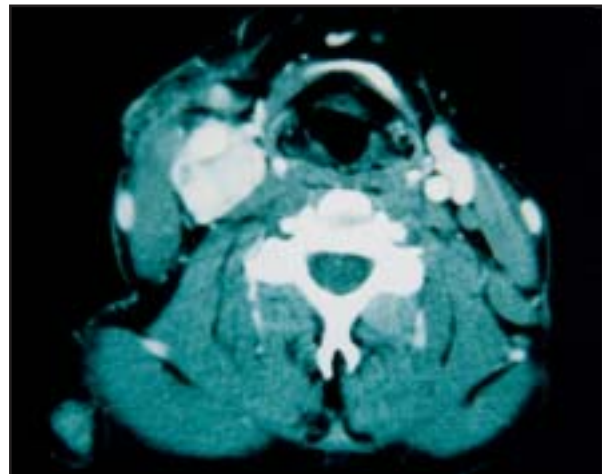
CT scan of the neck (infused).
